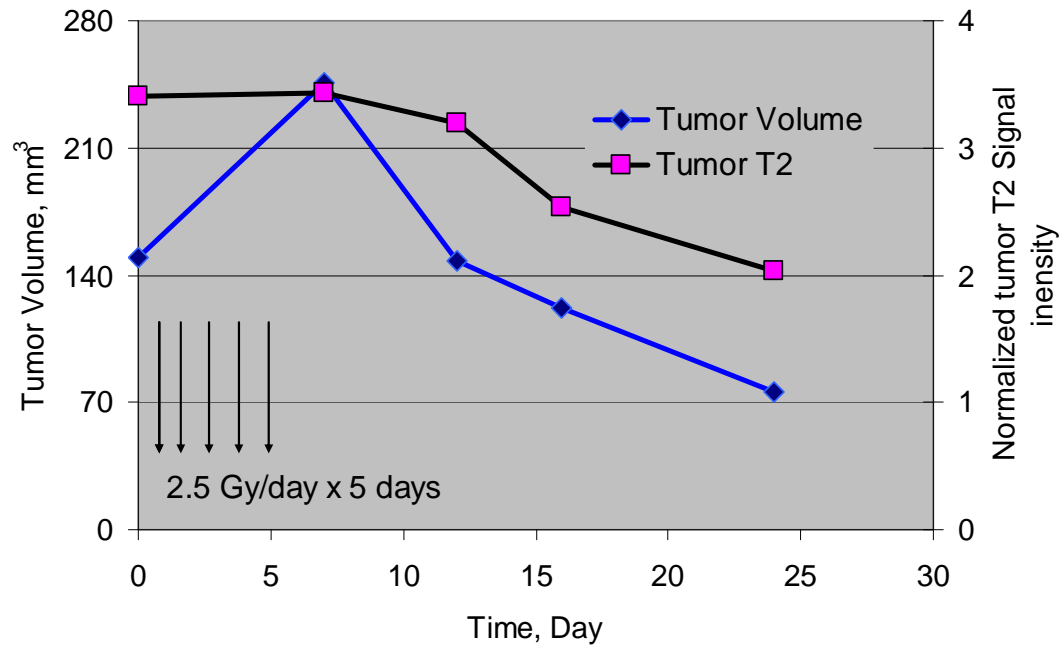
Tumor volume and MRI T2 values for a representative tumor treated by 2.5 Gy/day x 5 days
